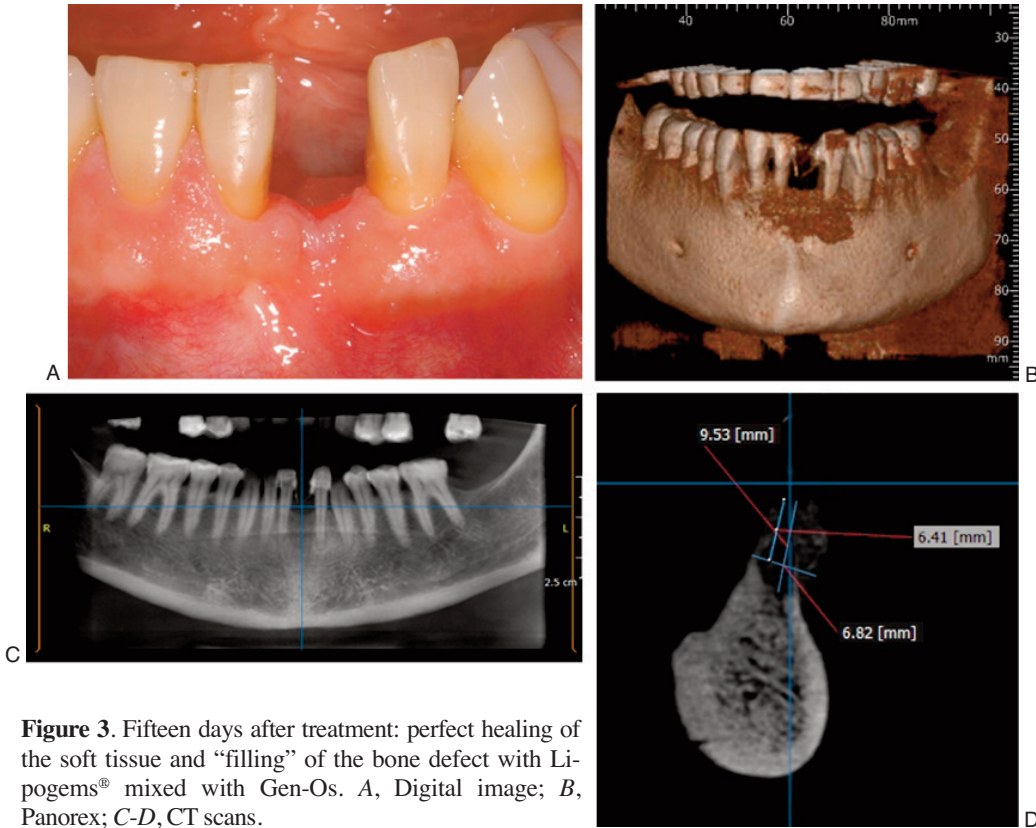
Fifteen days after treatment: perfect healing of the soft tissue and “filling” of the bone defect with Lipogems® mixed with Gen-Os. *A*, Digital image; *B*, Panorex; *C-D*, CT scans.
